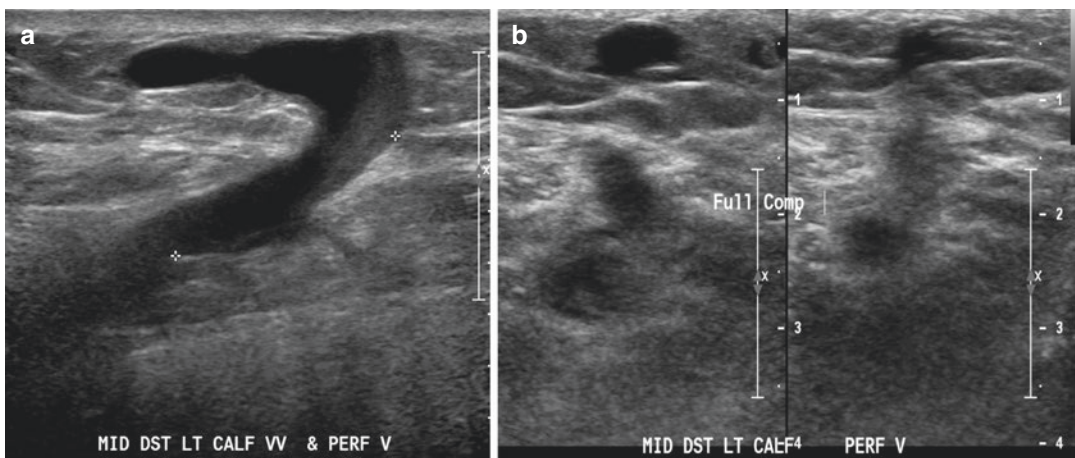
Compression ultrasound (B-mode imaging) showing (a) the vein with an open lumen and (b) full compression of the vein, indicating absence of thrombus
